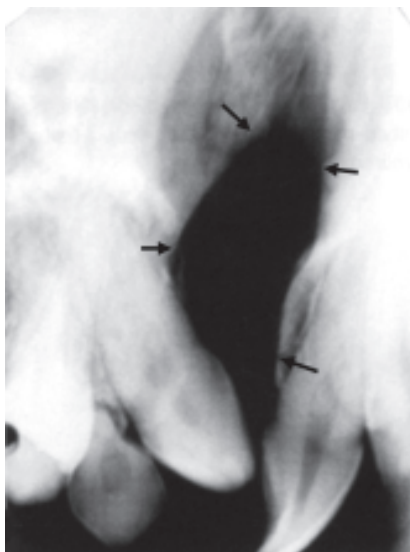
Periapical showing a unilateral cleft palate (arrows). Note lateral incisor is absent
